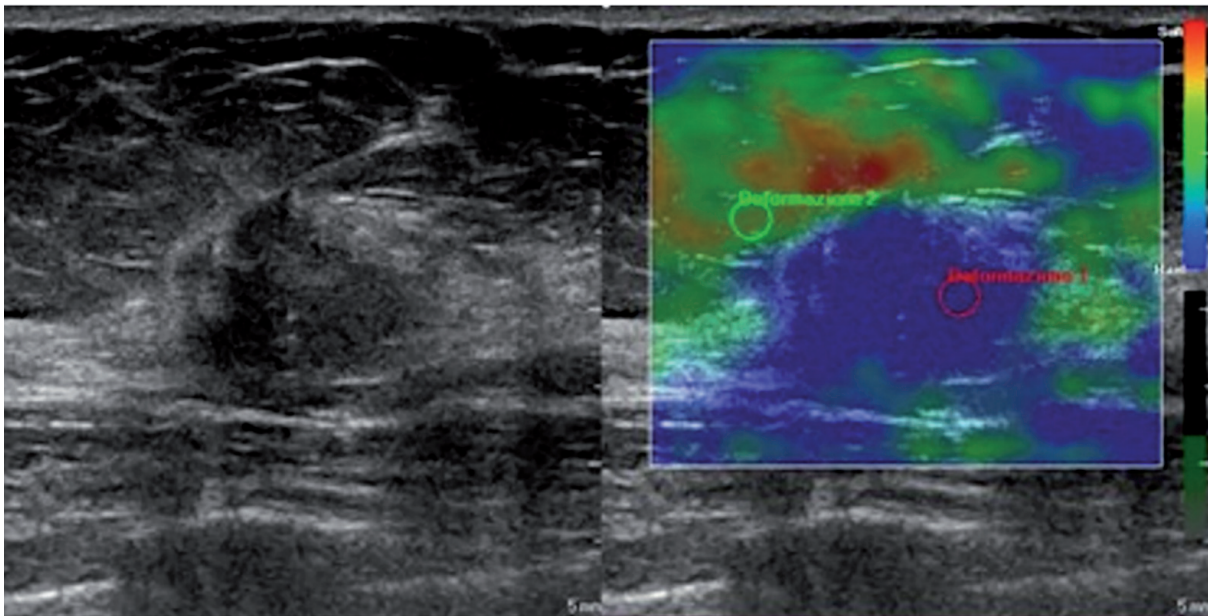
Score 4-5: The nodule shows a hardness pattern throughout the area examined (the entire nodule is homogeneously blue on elastosonographic evaluation).
